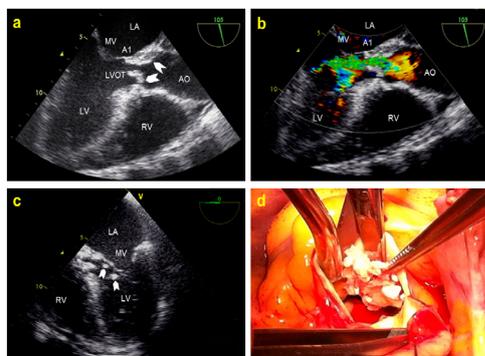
a: 2-D gray scale of mid esophageal long axis view (105°). b: 2-D color-Doppler of mid esophageal long axis view (105°). c: 2-D gray scale of mid esophageal five chamber view (0°). d: Intraoperative image of giant aortic endocarditis.
